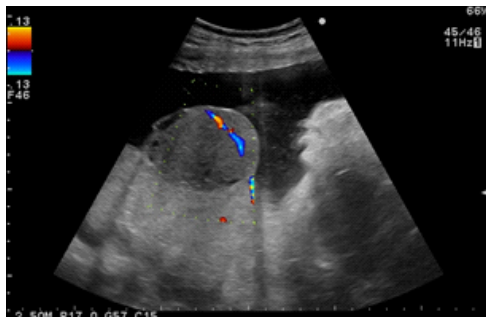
An ultrasound Doppler image in ANC 33 weeks of gestation showing well defined rounded hypo echoic lesion arising in placenta protruding into amniotic fluid with vascularity on Doppler.
